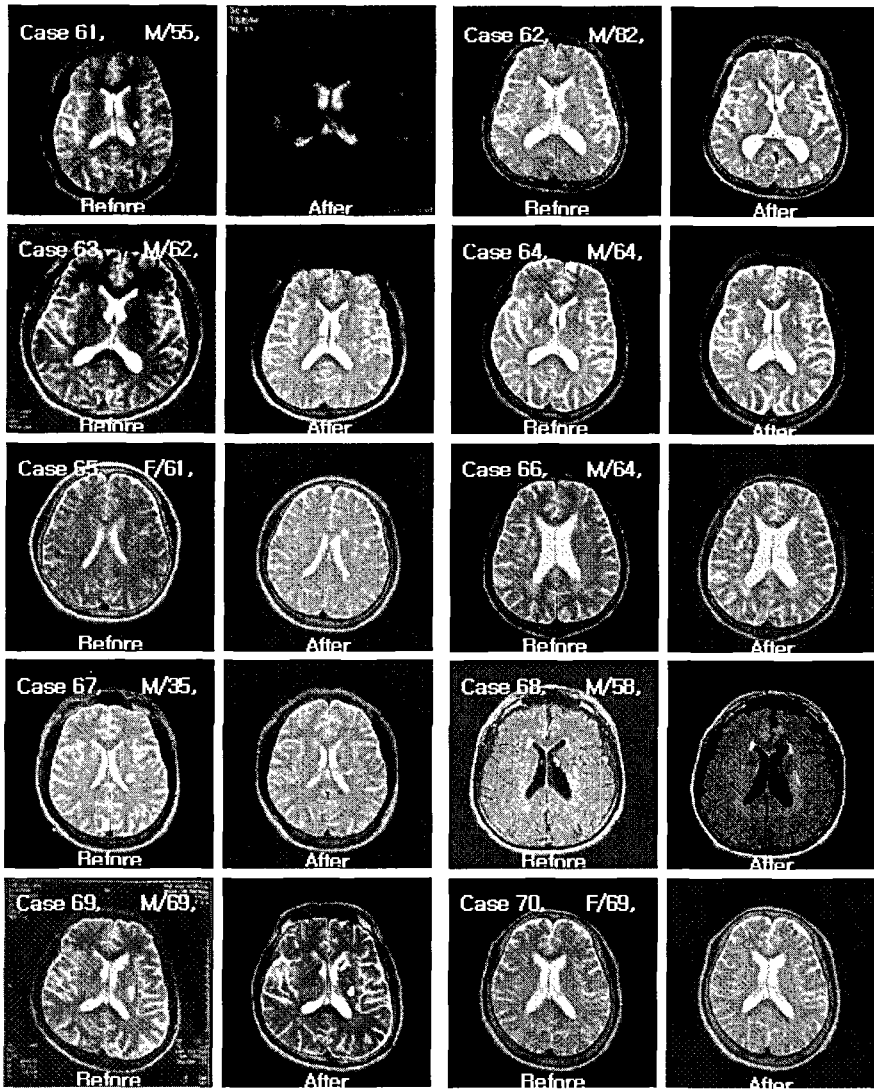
Brain MRI before and after 1 year of *Chunghyul-dan* medication in Cases 61 to 70. The above figures(Fig. 1 to Fig 6) show no new vascular lesions after 1 year of *Chunghyul-dan* medication compared to the old images.
